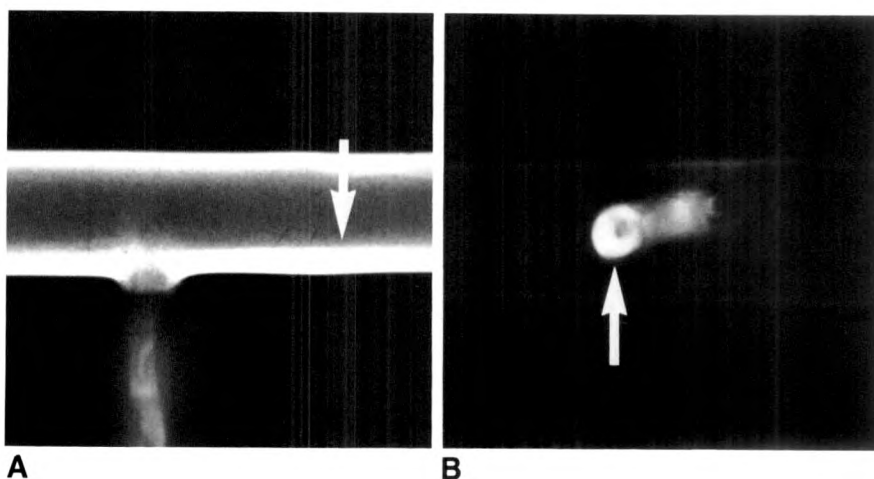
Radiograph of a T-shaped plastic model of common bile duct filled with gallbladder bile. Contrast material was injected into right end of horizontal limb.
